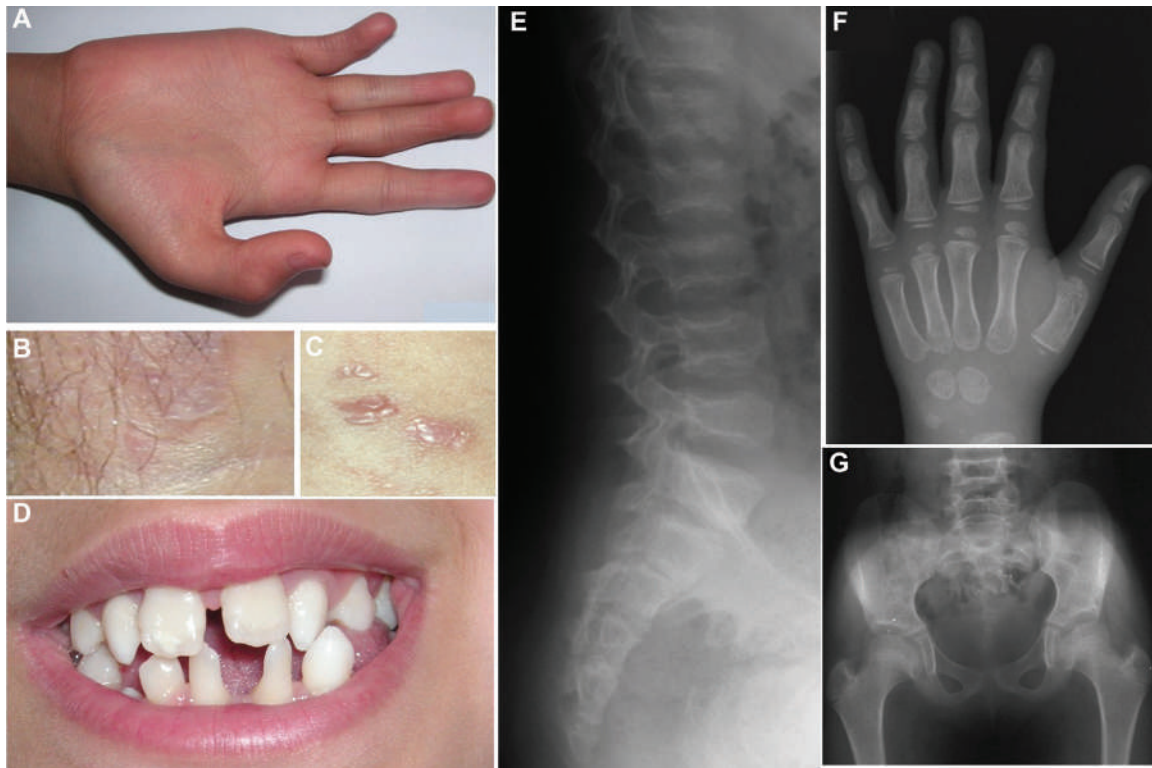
Clinical and radiological findings in patients with spEDS-*SLC39A13*. (A) Appearance of the hand in a 10.1 years old patient. Excessively wrinkled palm, thenar and hypothenar atrophy, tapering fingers, and contracted thumb. (B and C) Abnormal scar formation in two patients. (D) Abnormal dentition and hypodontia. (E) Radiograph of the low thoracic and lumbar spine in a patient aged 11.5 year with flattening, irregular endplates, and osteopenia of the vertebral bodies. (F) Radiograph of the hand of a 3.5 years old patient showing alterations of shape and flat epiphyses of the short tubular bones. (G) Radiograph of the pelvis of a 10 years old patient showing small ilia, mild flattening of the proximal epiphyses, short and wide femoral necks (Images kindly provided by Prof. Beate Albrecht and Prof. Nursel Elçioğlu, with permission).
